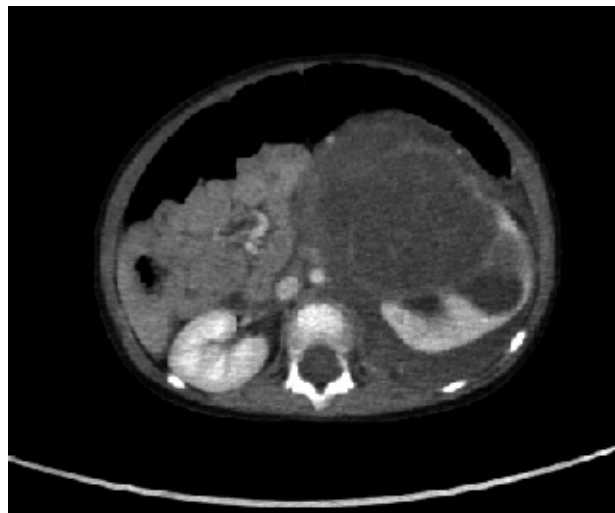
CT Chest – Abdomen – Pelvis with contrast
